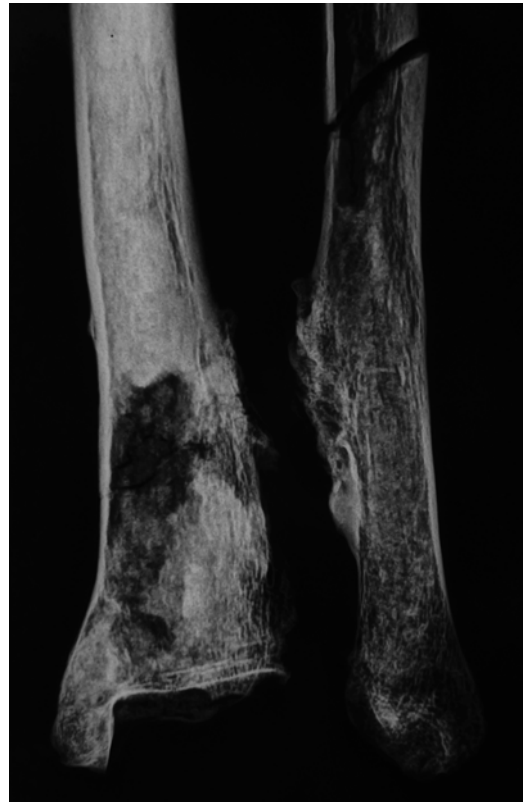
X-rays antero-posterior view of the ankle
